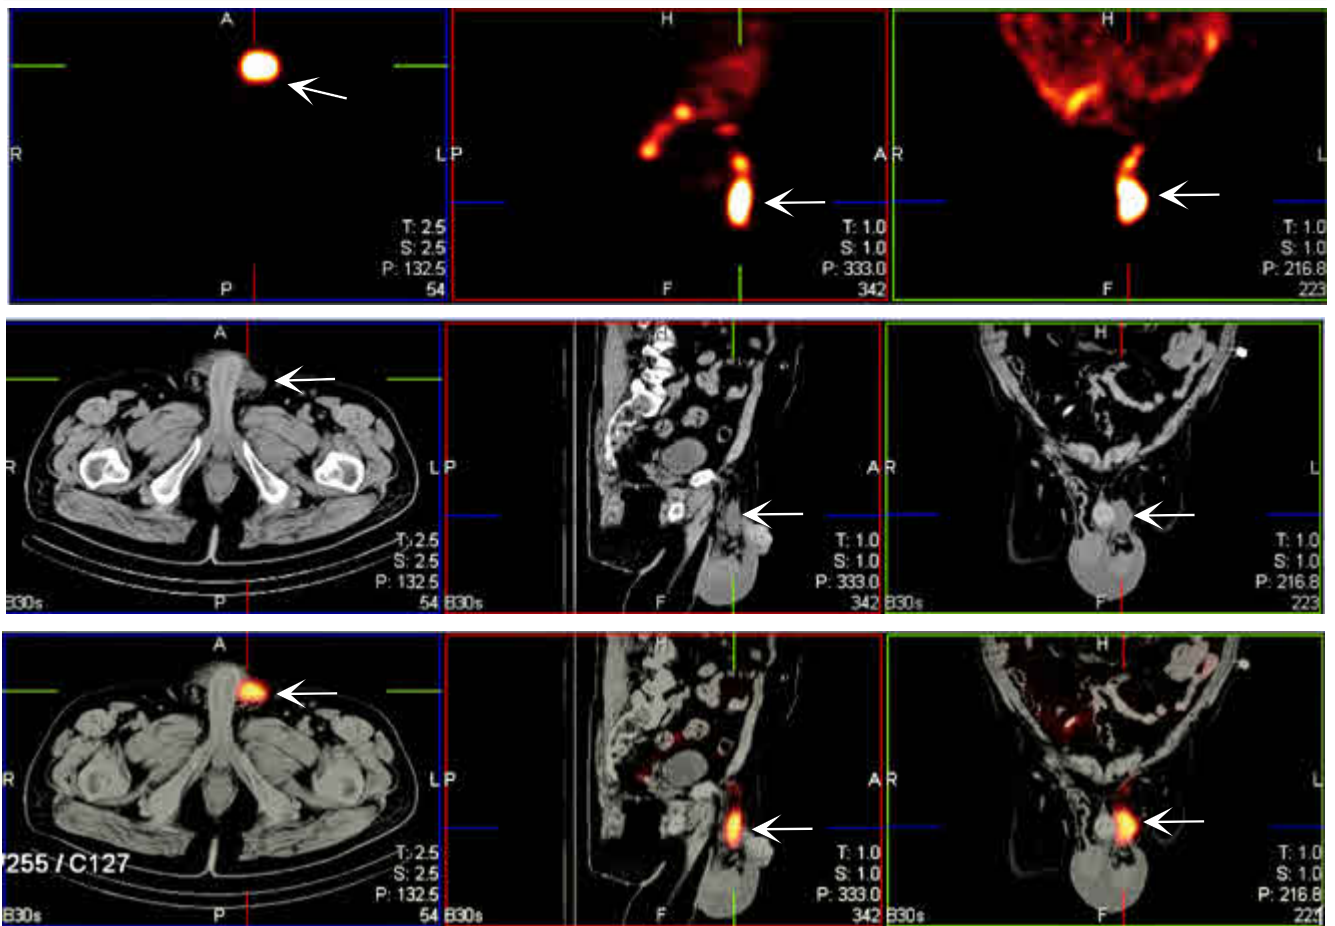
^{99m}Tc-Nanocolloid SPECT-CT scan images in the transaxial (left column), sagittal (middle column) and the coronal (right column) axes with SPECT (top row), CT (middle row) and fused SPECT-CT (bottom row) showing radioactive fluid in the left inguinal canal (arrows)
